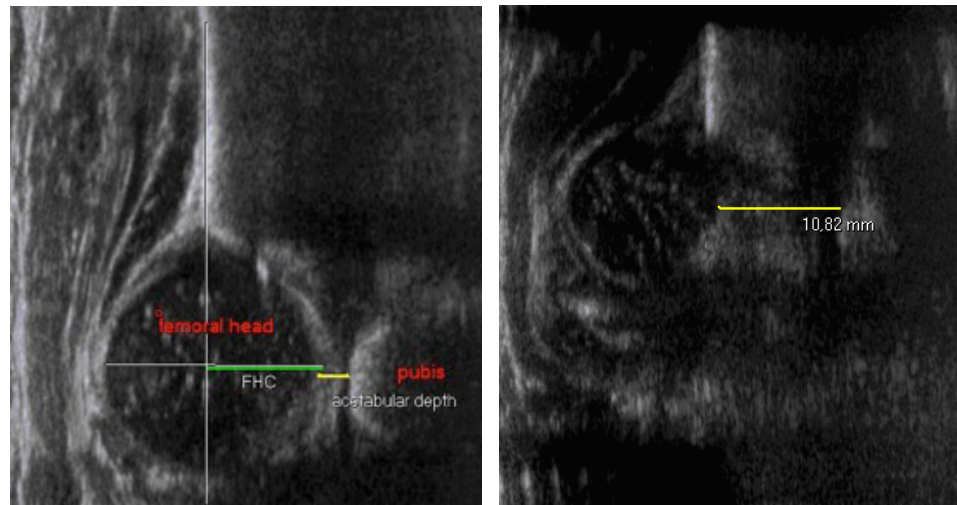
Measurement of femoral head coverage (FHC) and Pubo-femoral distance (Acetabular depth) on ultrasound in a normal hip (left); in a dislocated hip (right) with PFD > 6mm.
